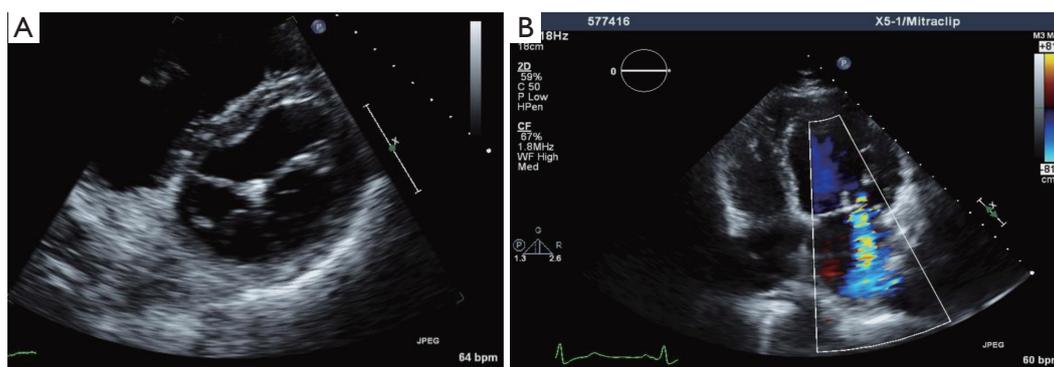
Transthoracic echocardiography images after percutaneous MitraClip insertion, showing double-orifice mitral valve (A, short axis view), and a colour Doppler image showing moderate residual mitral regurgitation (B, four chamber view).
